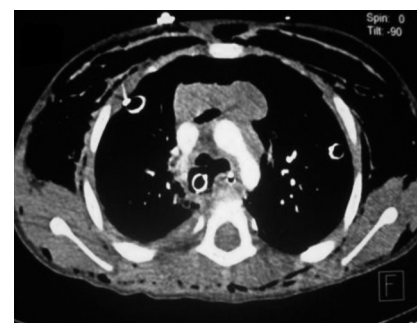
Chest CT scan showing the presence of bilateral pneumothorax and subcutaneous emphysema with chest drainage tubes. Deviation of the endotracheal tube relative to the tracheal route towards the posterior mediastinum.
